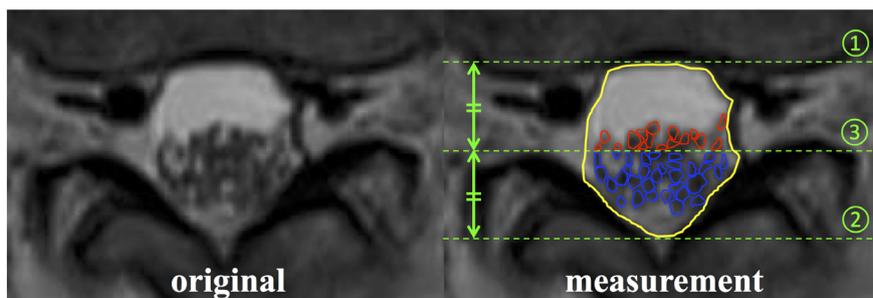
Measurements of the low-intensity areas in the ventral and dorsal halves in the lumbar dural sac. Focusing on lumbar MRI (T2-weighted images, axial view), we outlined the dural sac (yellow line) and defined the midpoint of its anteroposterior diameter (green dotted line). We measured the low-intensity areas in the ventral (red line) and dorsal (blue line) halves of the dural sac. We then calculated the proportion of the low-intensity area in the dorsal half of the dural sac to the total low-intensity area in the ventral and dorsal halves of the dural sac.
